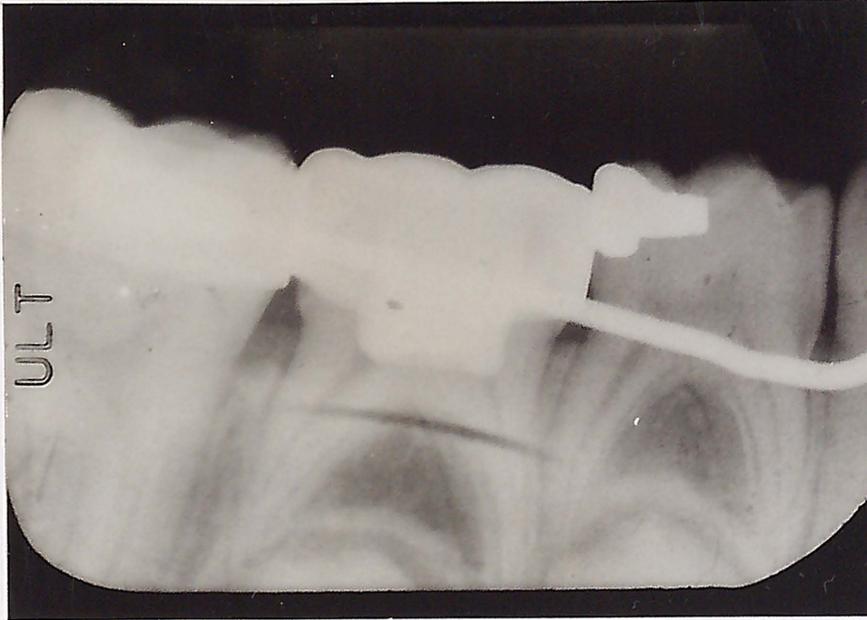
Pre- and postoperative radiographs of an electrosurgically pulpotomized tooth (#T) that was normal at last observation. The pulpotomy was performed at age 8 years, 4 months and the postoperative radiograph was taken at age 10 years, 3 months.
